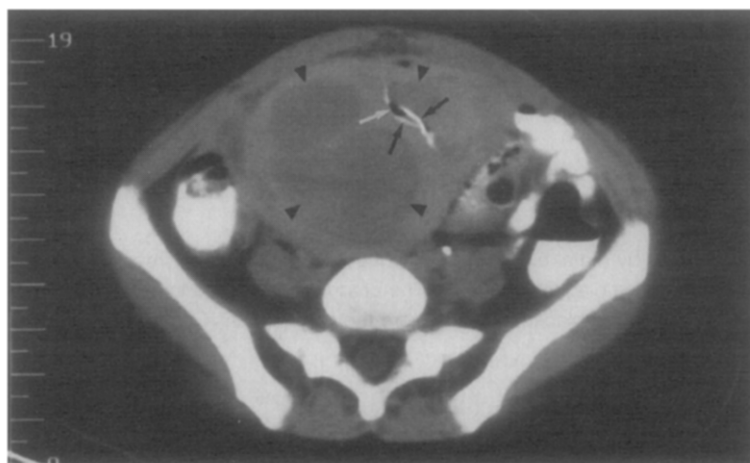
Computed tomography showed enlarged uterus with numerous rounded masses (*arrowheads*), intrauterine gas (*white arrow*) from uteroenteric fistula, and curvilinear foci (*black arrows*) that proved to be fetal skull parts.
